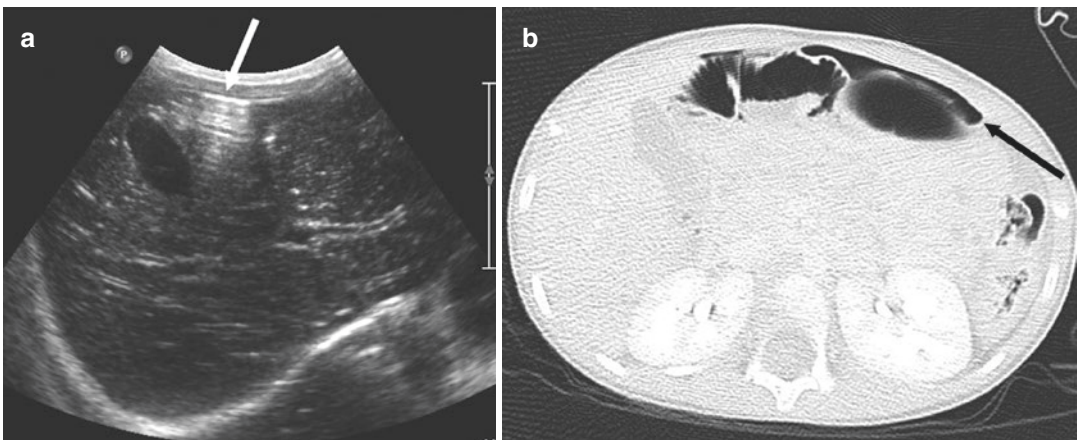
Four year old girl, Pedestrian hit by a car. (a) US transverse scan: pneumoperitoneum above the liver (white arrow). (b) CT with contrast: pneumoperitoneum
